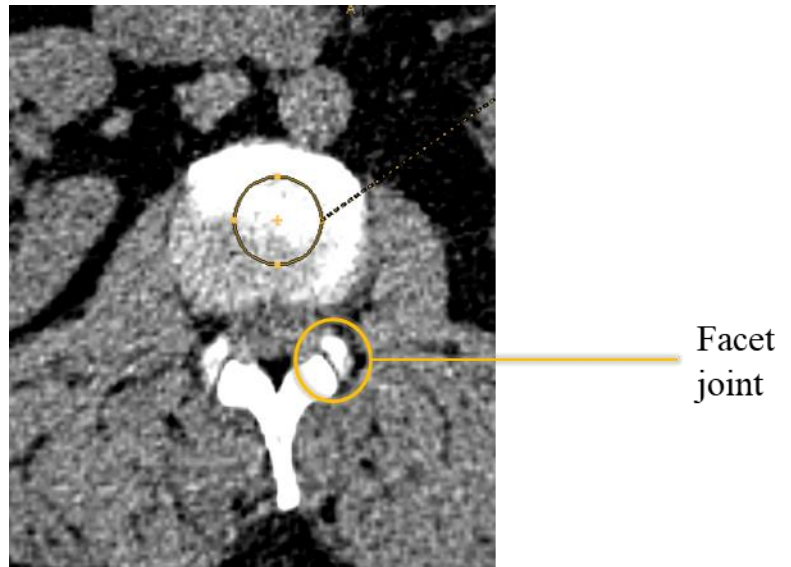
Transverse CT scan at the level of the IVD at level L2/L3
